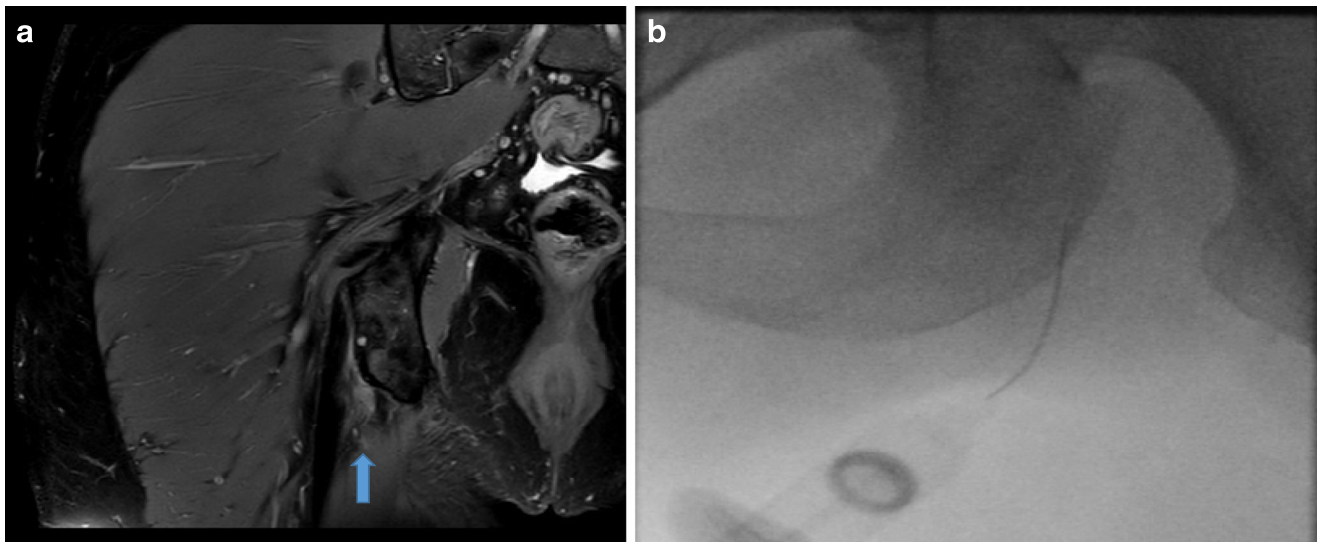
a Coronal proton density (PD) sequence MRI of a 42-year-old female with low-grade partial thickness tear of the right hamstring origin at ischial tuberosity (blue arrow). b Fluoroscopic-guided PRP injection at the right hamstring origin
